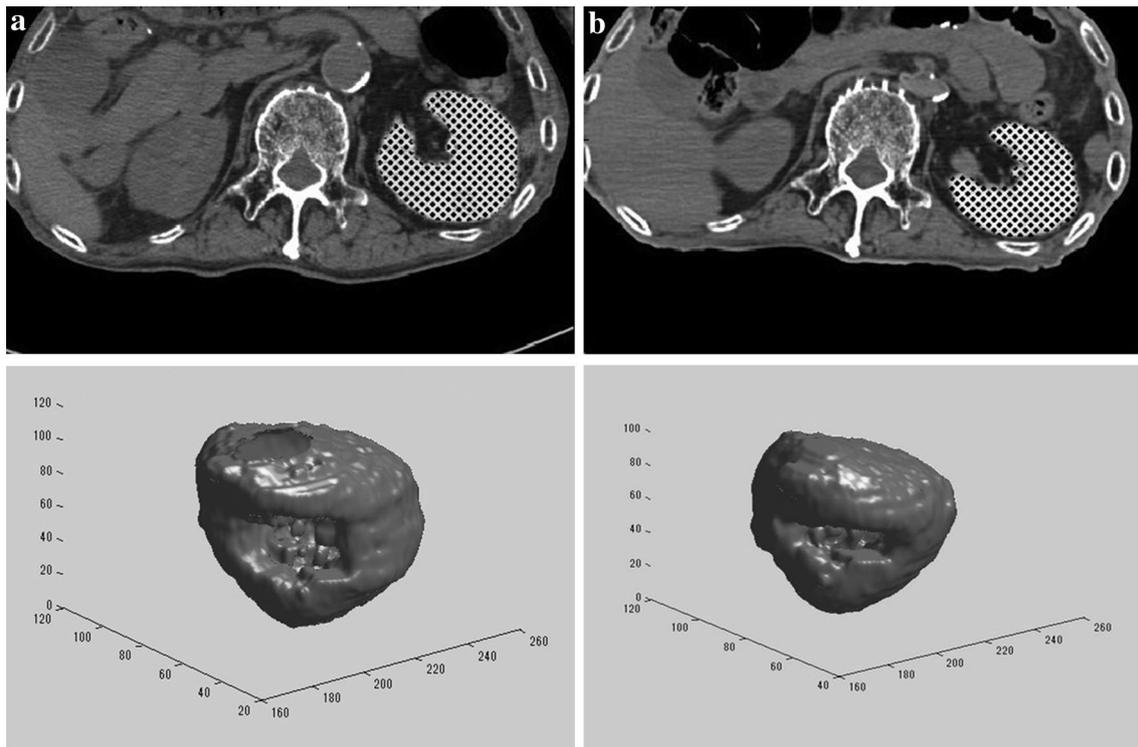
76-year-old male, who died from cardiac failure. Left renal volume measurements and three-dimensional images on antemortem CT (a) and postmortem CT (b). The volumes of the kidney on antemortem and postmortem were 214.8 cm^3 and 133.7 cm^3 , respectively
